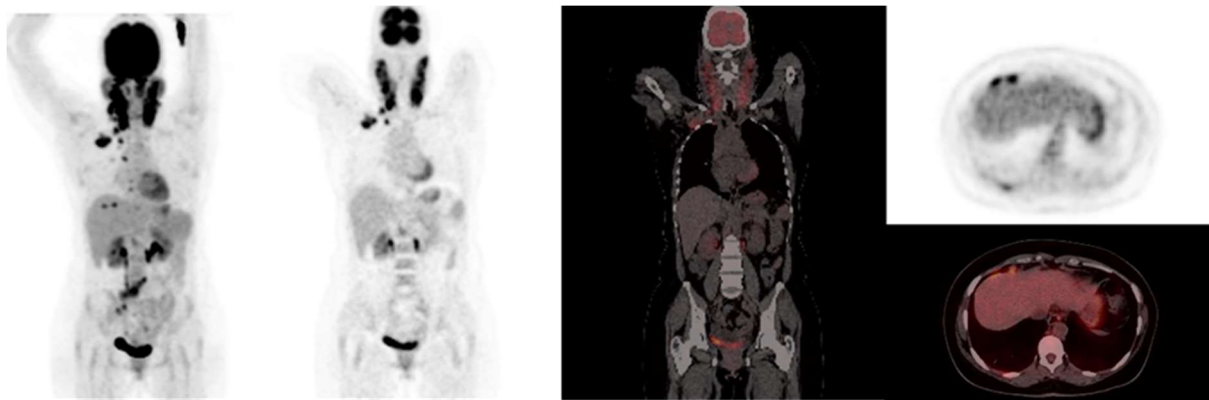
A 33-year-old female newly diagnosed with HIV infection (CD4+ T cell count = 12 cells/ μ L). Lymph node aspirate confirmed tuberculous lymphadenitis. FDG PET/CT showed widespread FDG-avid lymph nodes in multiple lymph node basins including bilateral cervical, mediastinal, mesenteric lymph node basins. There is involvement of the mesentery overlying the dome of the liver. These widespread nodal involvement with very intense FDG uptake suggest treatment-resistant phenotype.
